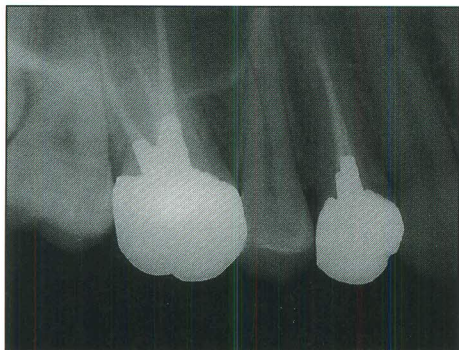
Post operative radiograph confirms the successful obturation of both teeth and the successful obturation of both teeth and the successful build-up of both crowns with amalgam extending into the cervical areas of each of the roots for enhanced retention. These can later be prepared for cast crowns and will function as such as cores for such crowns.
